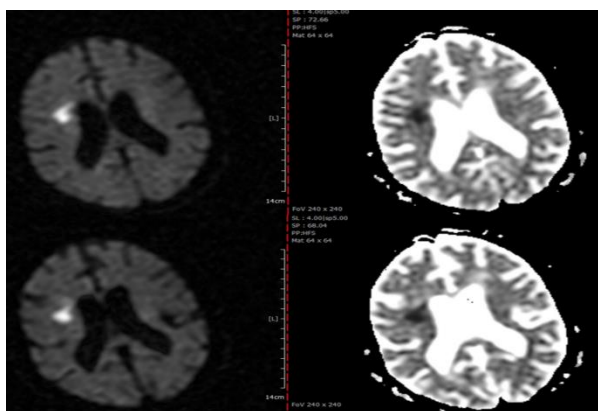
Restriction in diffusion-weighted imaging (DWI) after recurrent left hemiparesis attacks in right middle cerebral artery territory
